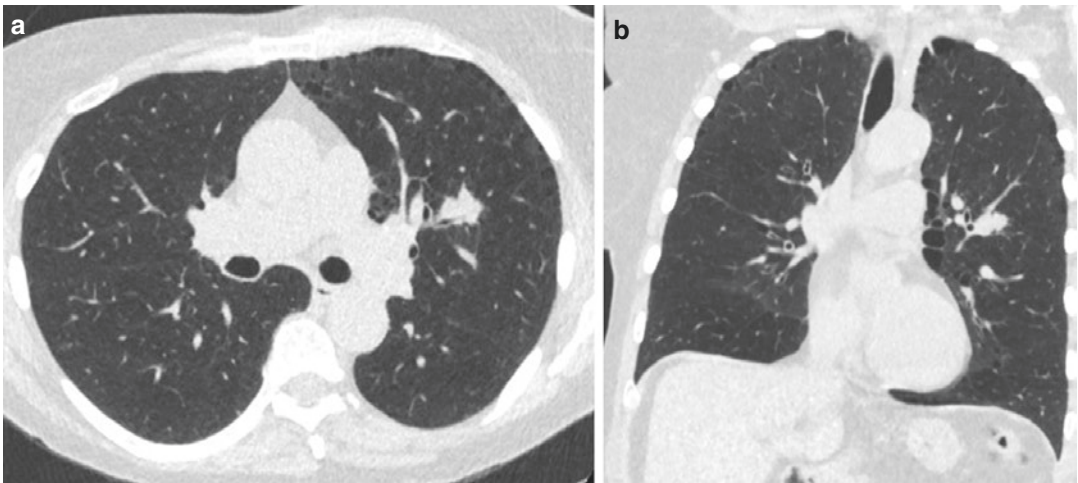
Transverse (a) and coronal (b) images of a 64-year-old woman (65 kg) who underwent low-dose CT for lung cancer screening (CTDIvol 0.85 mGy, DLP 32 mGy.cm). There is a lobulated 1.5 cm nodule in the left upper lobe with changes of paraseptal emphysema in bilateral lungs
